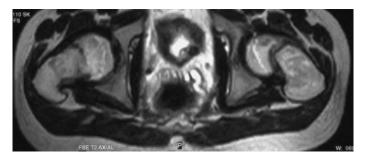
MRI of the pelvis showing slipped capital femoral epiphysis.
